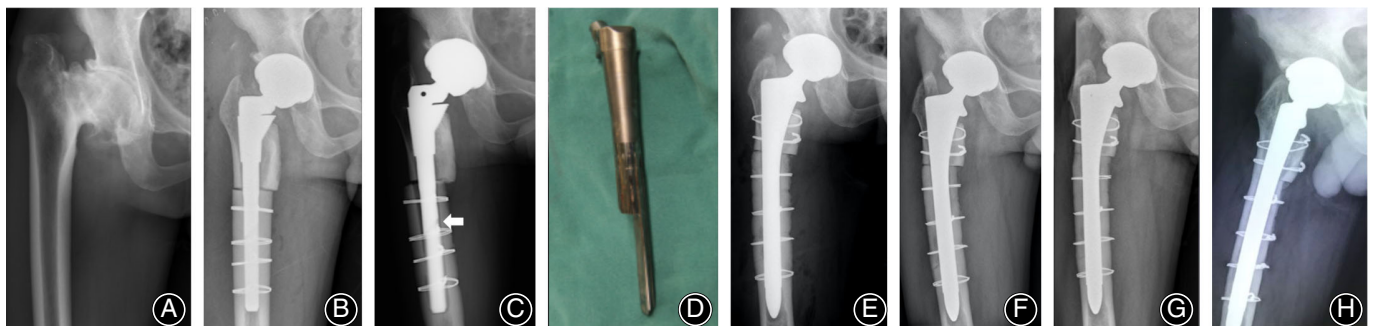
Radiographs of a 50-year-old man with osteoarthritis secondary to infection of the hip in childhood in the right hip. (A) Preoperative anteroposterior view. (B) Postoperative radiographic image at 1-week follow up. (C) Postoperative radiographic image at 2-year follow up. The hip had aseptic loosening of the femoral stem, resulting in local stress concentration at the distal end of the femoral component and breakage. (D) The fractured femoral stem intraoperatively. (E) Postoperative radiographic image at 1-week follow up. The hip underwent cementless total hip arthroplasty with Solution femoral stem (DePuy). (F) Postoperative radiographic image at 1-year follow up. The acetabular and femoral components were stable and in a satisfactory position. (G) Postoperative radiographic image at 2-year follow up. The acetabular and femoral component were fixed firmly. (H) Postoperative radiographic image at 5-year follow-up. The acetabular and femoral components were stable without radiolucent line.
